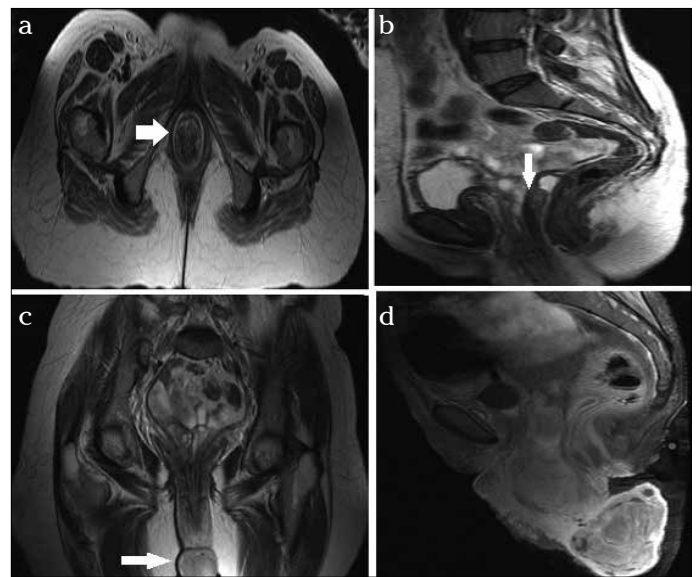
a-d. Axial T2-weighted MRI shows Bull's eye sign (solid arrow), i.e., hypointense fundus outlined by hyperintense layer of fluid within the vagina (a), sagittal T2-weighted MRI shows inverted U-shaped uterine cavity (solid arrow), a mirror image of a normal anatomical configuration (b), coronal T2-weighted MRI shows inverted uterus with a well-defined mass lesion at the top of the uterine fundus (solid arrow) (c), sagittal post contrast T1-weighted MRI shows intense homogeneous enhancement of both the mass and normal uterus (d)
